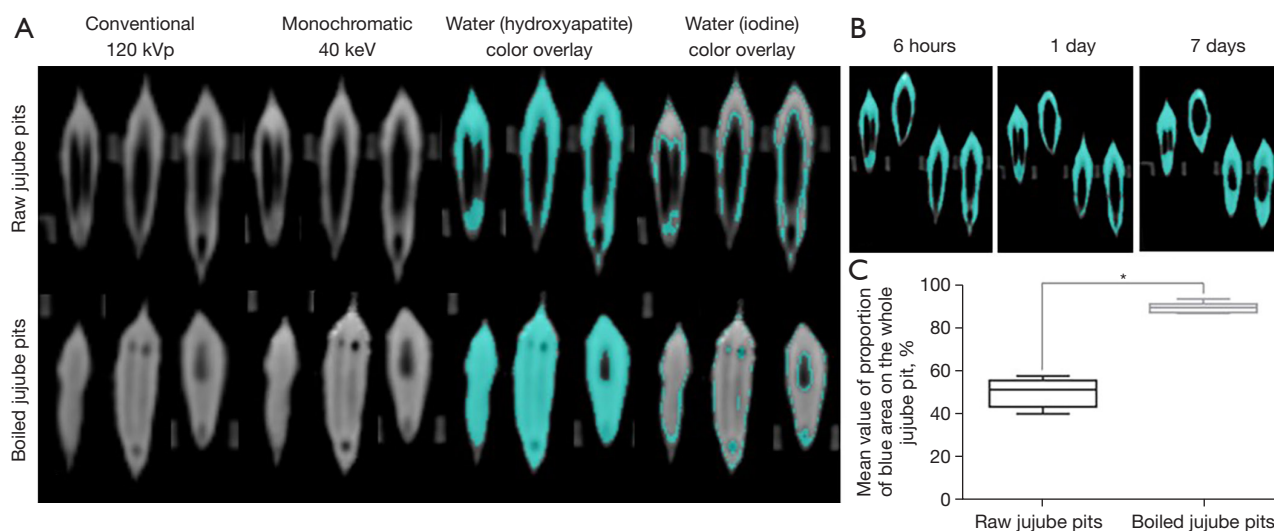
Changes of Jujube pits on CT images over immersion time. (A) Different sequence of three raw jujube pits (top row) and three boiled jujube pits (bottom row) in the same CT study after jujube pits immersion for 6 h. Note that the interior density varies greatly between the raw and boiled jujube pits. The blue area of water (hydroxyapatite) images shows better concordance with the high-density area of conventional 120 kVp images and monochromatic 40 keV images than water (iodine) images. (B) Water overlay images after raw jujube pits soaked for 6 h, 1 d, 7 d. The blue area expanded inward over time, while the inner hollow area shrunk. (C) Analysis of blue area percent on water (hydroxyapatite) images between raw and boiled Jujube pits. *, a P value <0.05, indicates a significant difference. CT, computed tomography.
